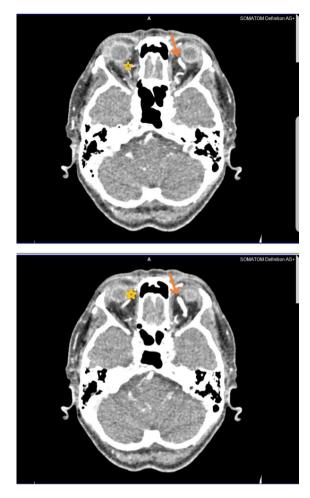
Computed tomography angiogram (CTA) images showing prominent superior ophthalmic veins on the right side (yellow stars) and tortuously dilated superior ophthalmic veins on the left side (orange arrows).
